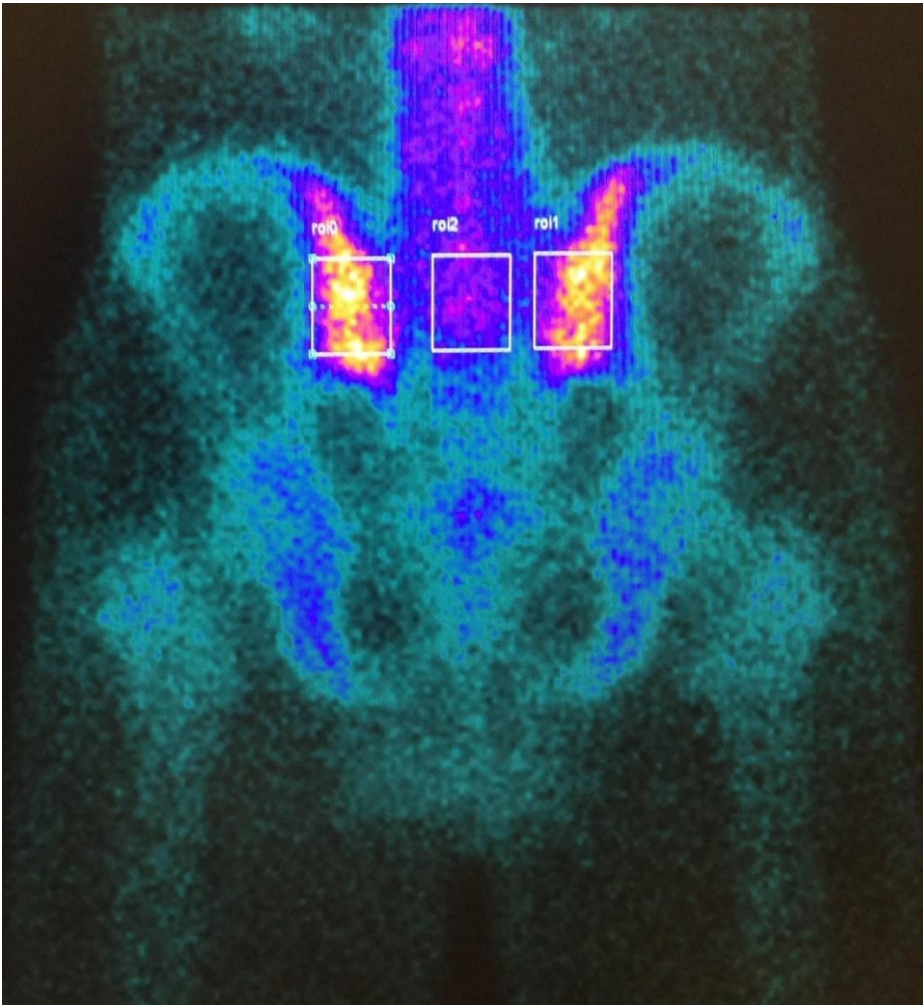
Rectangular ROI method. Same shaped rectangular ROI were placed on both sacroiliac joints and sacrum in posterior pelvis image of bone scintigraphy.
